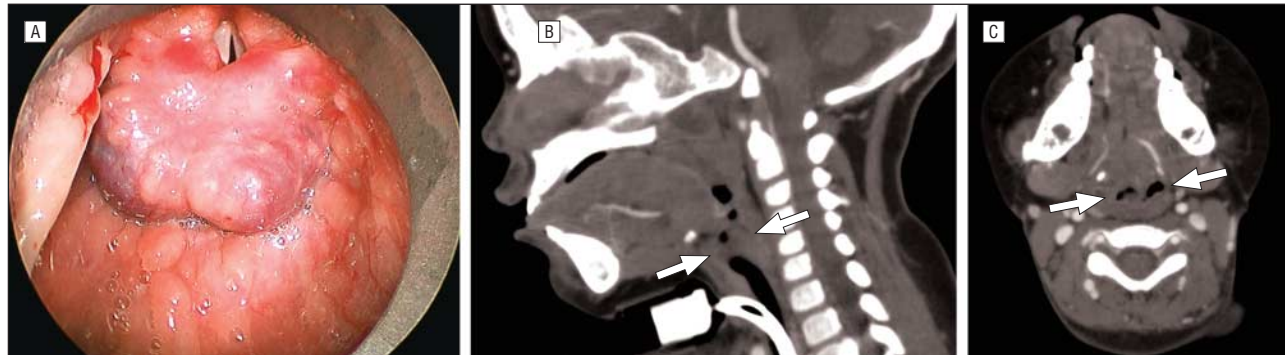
Postcricoid venous malformation. A, Endoscopic view of a postcricoid venous malformation. B, Sagittal computed tomographic angiogram demonstrating a nonenhancing mass (arrows). C, Axial computed tomographic angiogram demonstrating postcricoid fullness without enhancement (arrows).
